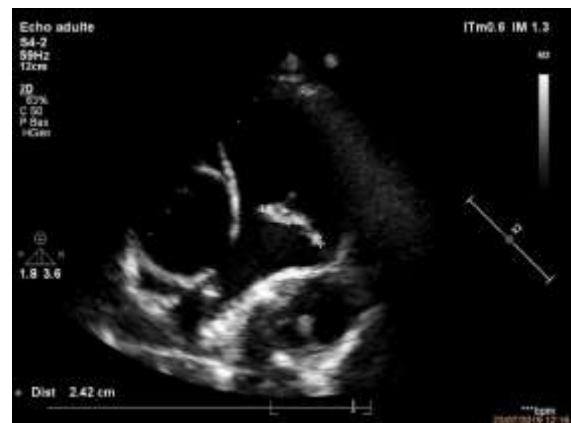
Parasternal short-axis view centered on the pulmonary artery, its branches and the arterial canal highlighting vegetations in the trunk of the pulmonary artery.
